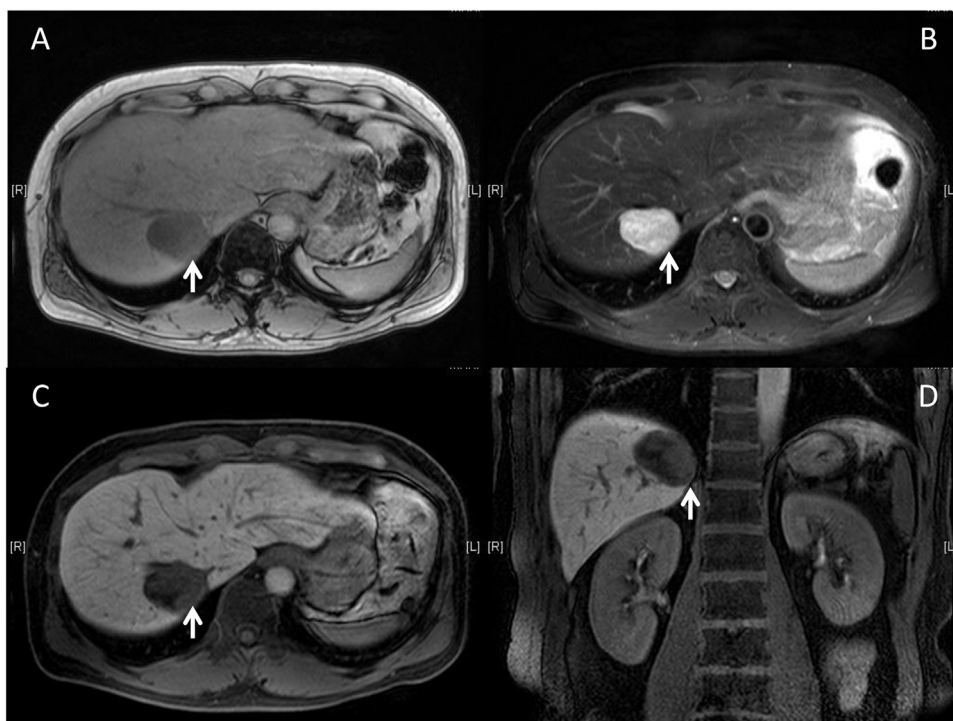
A, B: Magnetic resonance images. A) A T1-weighted image shows a hypointense tumor (arrow). B) A T2-weighted image shows a hyperintense tumor (arrow). C, D: Gadolinium-ethoxybenzyl-diethylenetriamine penta-acetic acid-enhanced (EOB) MRI shows a defect (arrow) during the hepatobiliary phase. C) Axial image. D) Coronal image.
